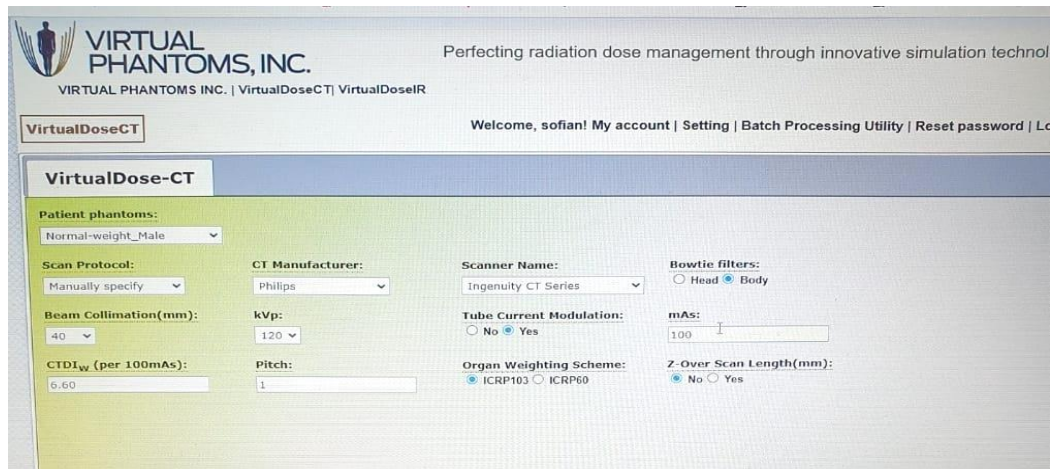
Shows the interface of Virtual Dose™ CT
